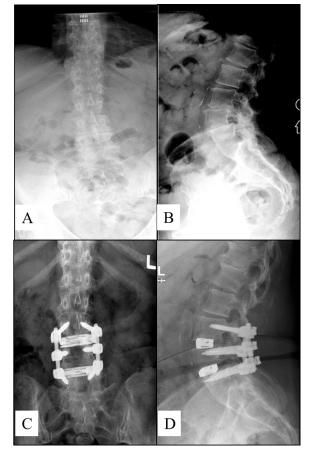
Preoperative anteroposterior (AP) (A) and lateral (B), and postoperative AP (C) and lateral (D) radiographs of a two-level MIS-LLIF at L3-L4 and L4-L5.
